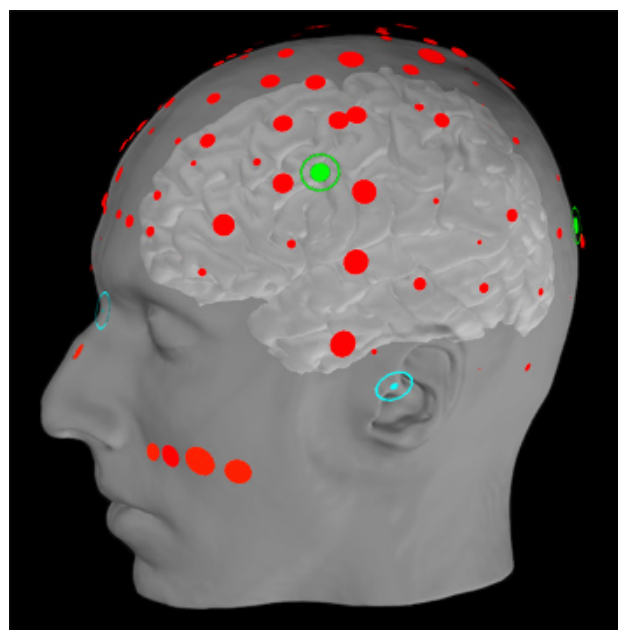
MNE software used to facilitate EEG channels and HPI locations co-registration onto one subject's MRI co-ordinate space.
